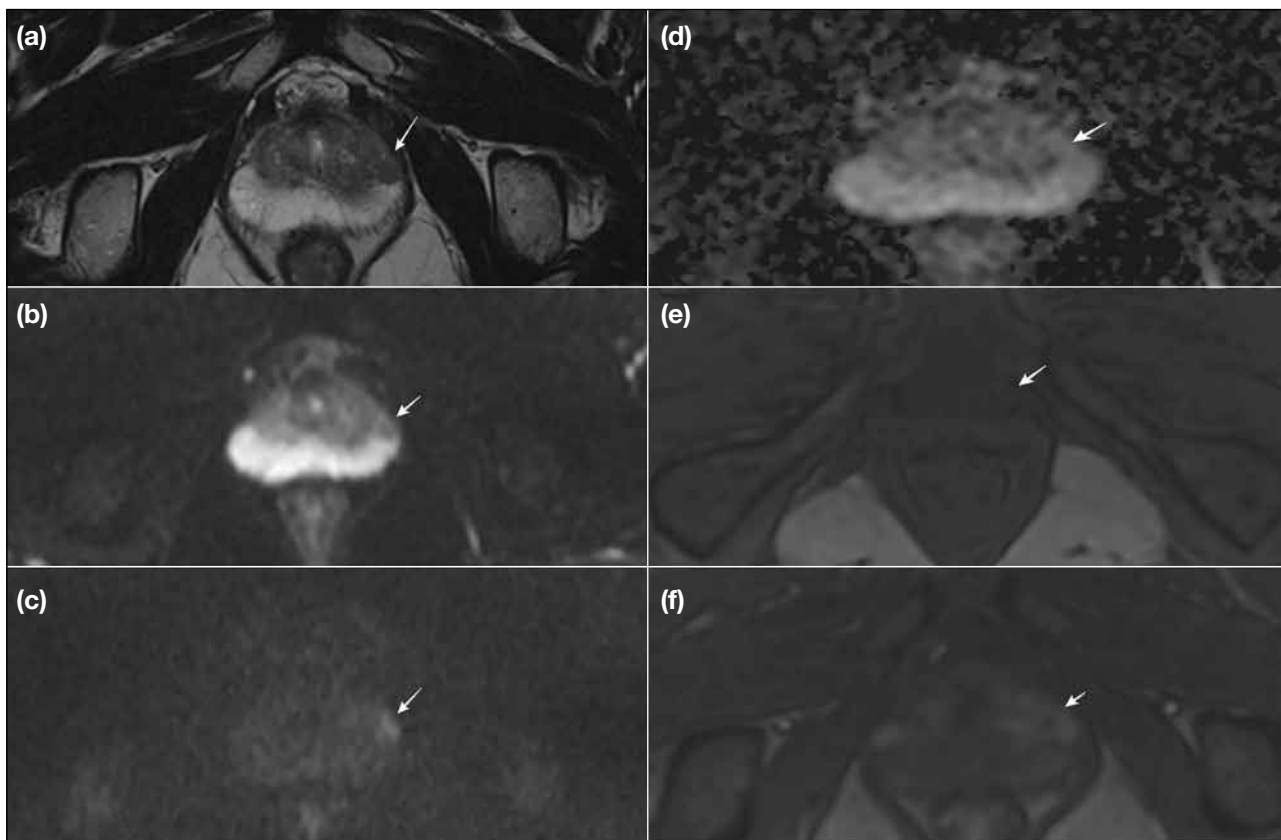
A 56-year-old man with prostate-specific antigen level of 5.6 ng/mL. Arrows indicated a Prostate Imaging Reporting and Data and System (PI-RADS) version 2.1 category 4 lesion visible in the peripheral zone. (a) Axial T2-weighted magnetic resonance (MR) image showing the lesion in the left-mid peripheral zone. The dimension of the lesion is 1.0 cm, which is consistent with a PI-RADS score of 3 on T2-weighted imaging. (b and c) show that the lesion is hypointense on diffusion-weighted imaging (DWI) [$b = 50 \text{ s/mm}^2$] and hyperintense on DWI ($b = 1800 \text{ s/mm}^2$). (d) Apparent diffusion coefficient map indicates that the lesion is mildly hypointense, giving it a PI-RADS score of 3 on DWI. (e) Pre-contrast T1-weighted and (f) dynamic contrast-enhanced MR images show early enhancement within the same location as the lesion in (a-d) with early enhancement for overall PI-RADS version 2.1 score of 4. Transrectal ultrasound-guided cognitive imaging fusion biopsy was defined as International Society of Urological Pathology score of 1.
